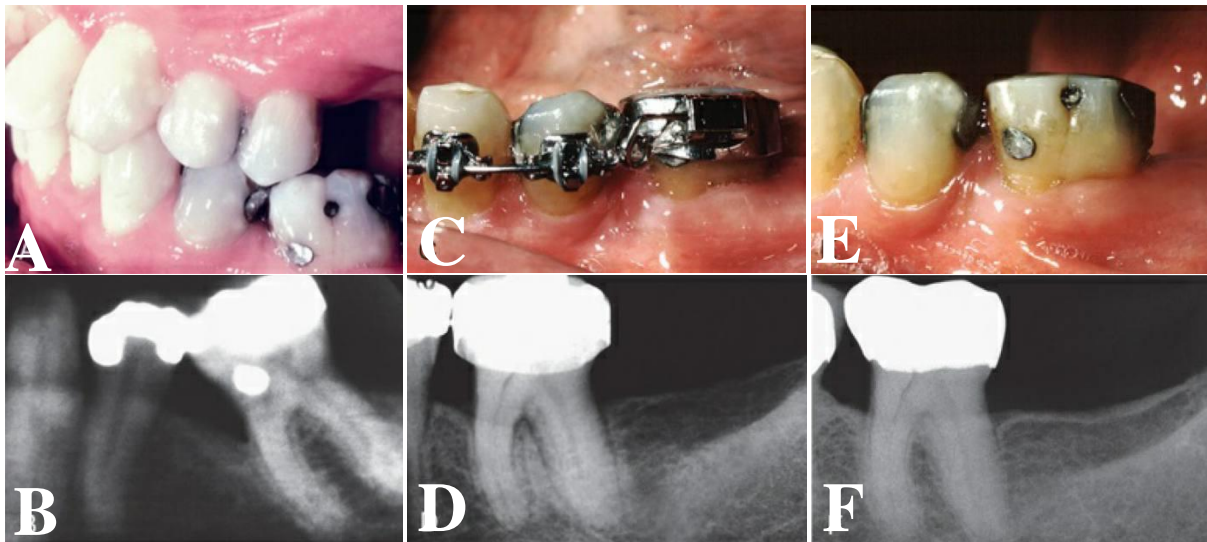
(Newman *et al.*, 2019). This patient was missing the mandibular left second premolar, and the first molar had tipped mesially. (A): pre-treatment intraoral photograph. (B): Pretreatment periapical radiograph revealed a significant hemiseptal osseous defect on the mesial side of the molar. (C): To eliminate the defect, the molar was erupted, and the occlusal surface was equilibrated (D): The eruption was stopped after the bone defect was leveled. (E): Post-treatment intraoral photograph (F): And periapical radiograph show that the periodontal health was improved by orthodontic correction of the hemiseptal defect.
